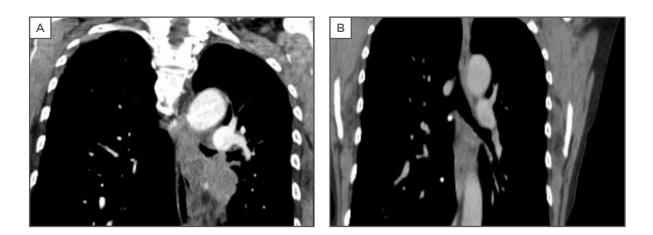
A) Computed tomography scan image showing recurrent obstruction secondary to adenocarcinoma of the lung. B) Computed tomography scan image after stent removal, after 4 months on erlotinib treatment.
